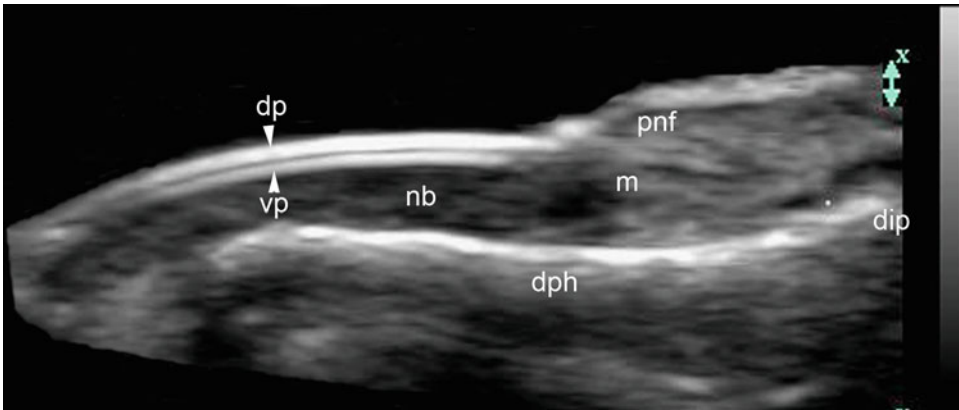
Normal nail sonography (Courtesy of Ximena Wortsman, Chile)
